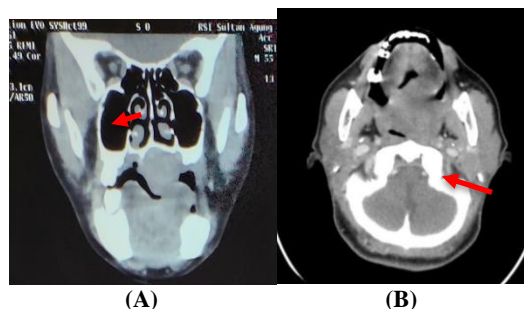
The Isodense Lesion in the Palate To The Oropharyngeal Region On Computed Tomography with Contrast ; (A) Coronal View, (B) Axial View
